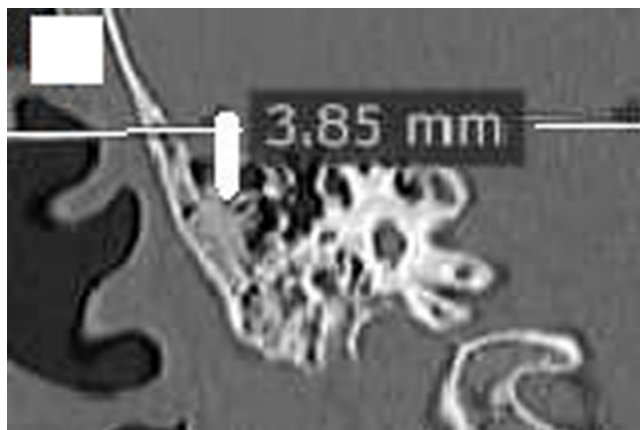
Coronal cut of right temporal HRCT, showing the vertical distance (3.85 mm) between the lower edge of the temporal lobe in the mastoid, and a line passing through the upper edge of the petrous bone, indicating a good position of the Tegmen (it was scored 0 marks). HRCT, high-resolution CT scan.
